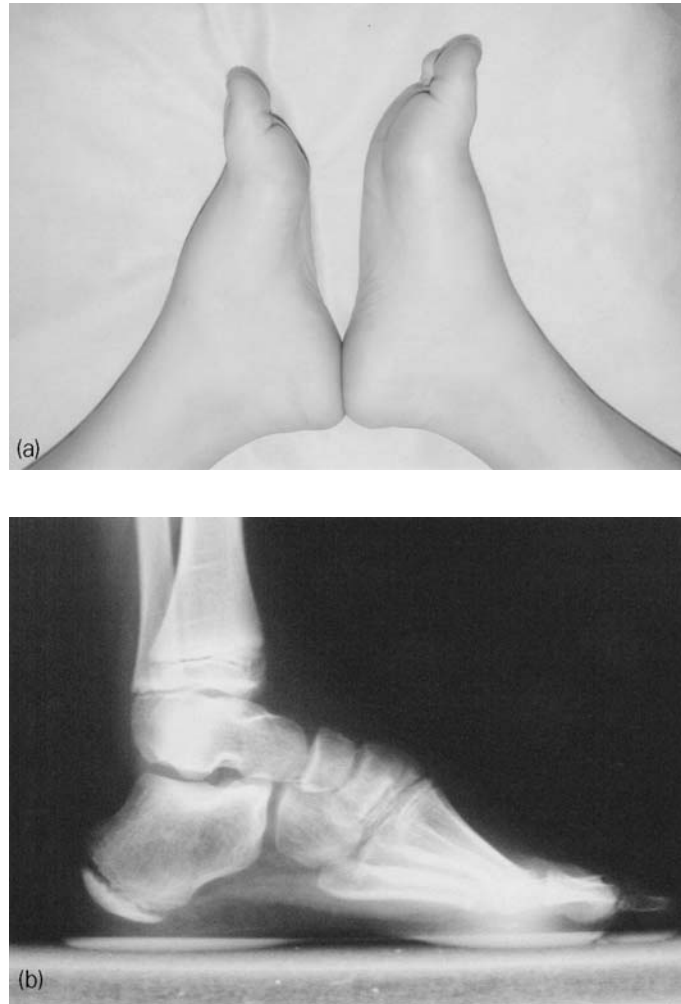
A 12-year-old boy with posttraumatic shortening of the left foot resulting from lesions of the cuneiform bones and phalanges of the third and fourth toes. (a) Clinical photograph of the patient's feet before treatment. (b) Lateral radiograph of the left foot before surgery. (c) Lateral radiograph after lengthening following cuboid-cuneiform osteotomy. (d) Lateral radiograph after treatment showing new regenerated bone in the midfoot. (e) Clinical photograph after lengthening. (f) Plantar view of the patient's feet, showing improvement of the foot length after treatment.
